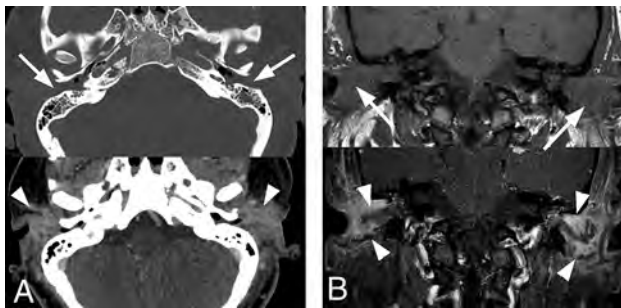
Bilateral external otitis. A 44-year-old woman presented with severe bilateral ear pain and drainage with conductive hearing loss. Clinically, there was marked inflammatory thickening of the EACs bilaterally. *Pseudomonas* species were cultured from the external auditory canals bilaterally. The patient was treated with IV vancomycin and piperacillin/tazobactam for 4 days followed by 2 weeks of oral ciprofloxacin. Symptoms resolved at 3 weeks without additional imaging work-up. A, Axial enhanced CT images are shown. Upper image with bone windows shows marked opacification of the EACs (arrows). The lower image with a soft-tissue filter shows marked inflammation of the EACs and periauricular tissues (arrowheads). B, The upper coronal T1 image shows marked opacification and thickening of the EACs (arrows) and associated opacification of the middle ear cavities. The lower image depicts postcontrast fat-saturated T1 images. A discrete mass is not identified. However, there is marked enhancement along the walls of the EACs (arrowheads), compatible with otitis externa.
